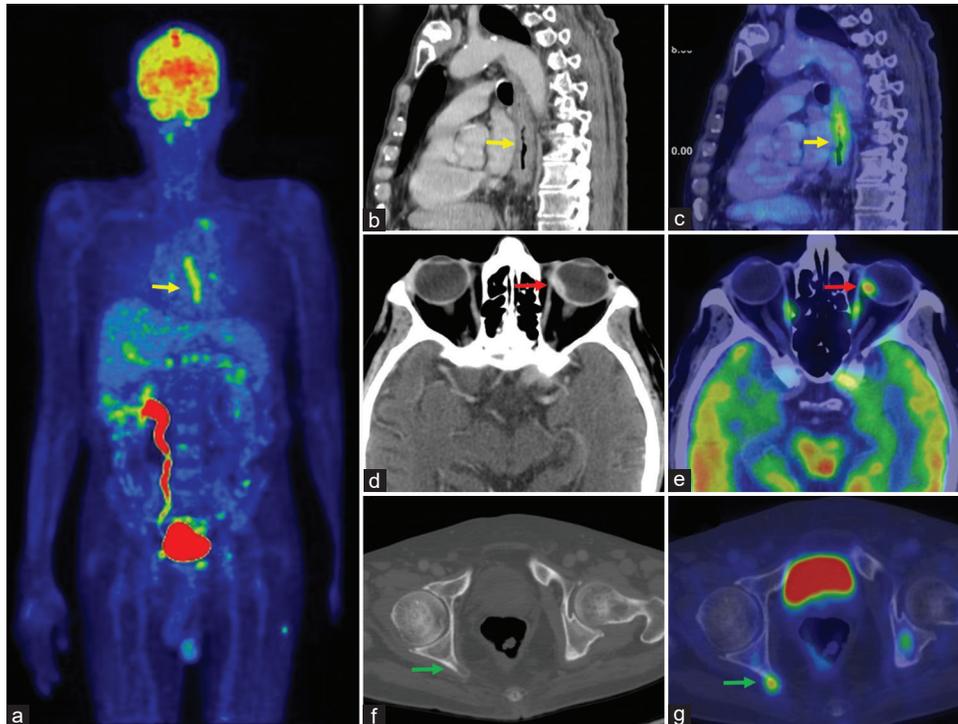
Whole bodyPETMIPshowing residual disease in the esophagus [small yellowarrows, a-c], an FDG avidenhancinglesion in the left choroid [red arrows, d and e]withmultiplenewactiveskeletallesions [green arrows,f and g]
